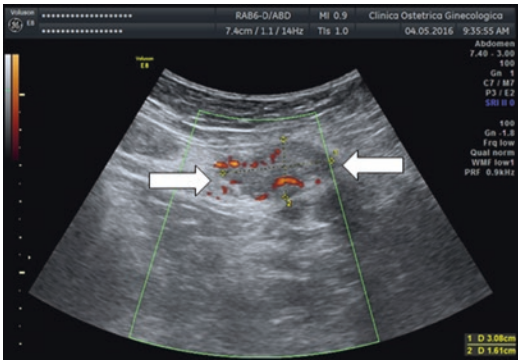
Color Doppler ultrasonographic images (straight arrows) of a scar endometriosis in a 39-year-old woman with one previous cesarean section 6 years before
